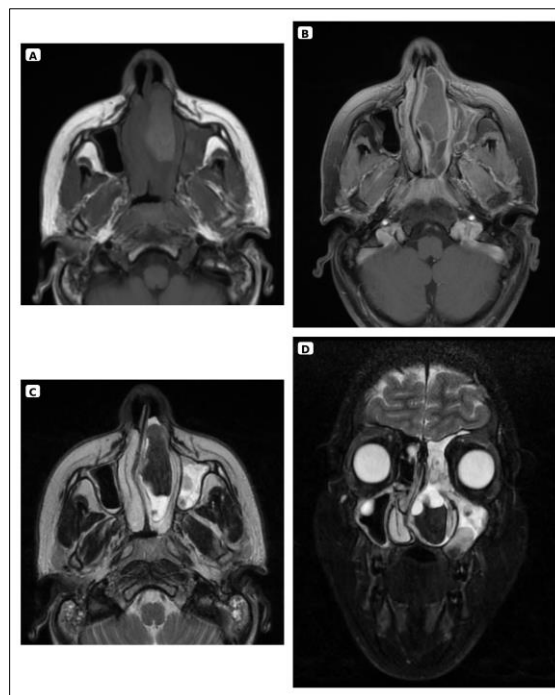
MRI findings of the left sinonasal lesion. A) Axial T1-weighted image shows predominantly intermediate-to-high signal intensity. B) Axial fat-suppressed contrast-enhanced T1-weighted image shows no appreciable enhancement of the lesion core, with peripheral mucosal enhancement. C) Axial T2-weighted image shows marked low signal intensity/signal void. D) Coronal fat-suppressed T2-weighted image confirms unilateral sinonasal extension and associated inflammatory sinus changes
